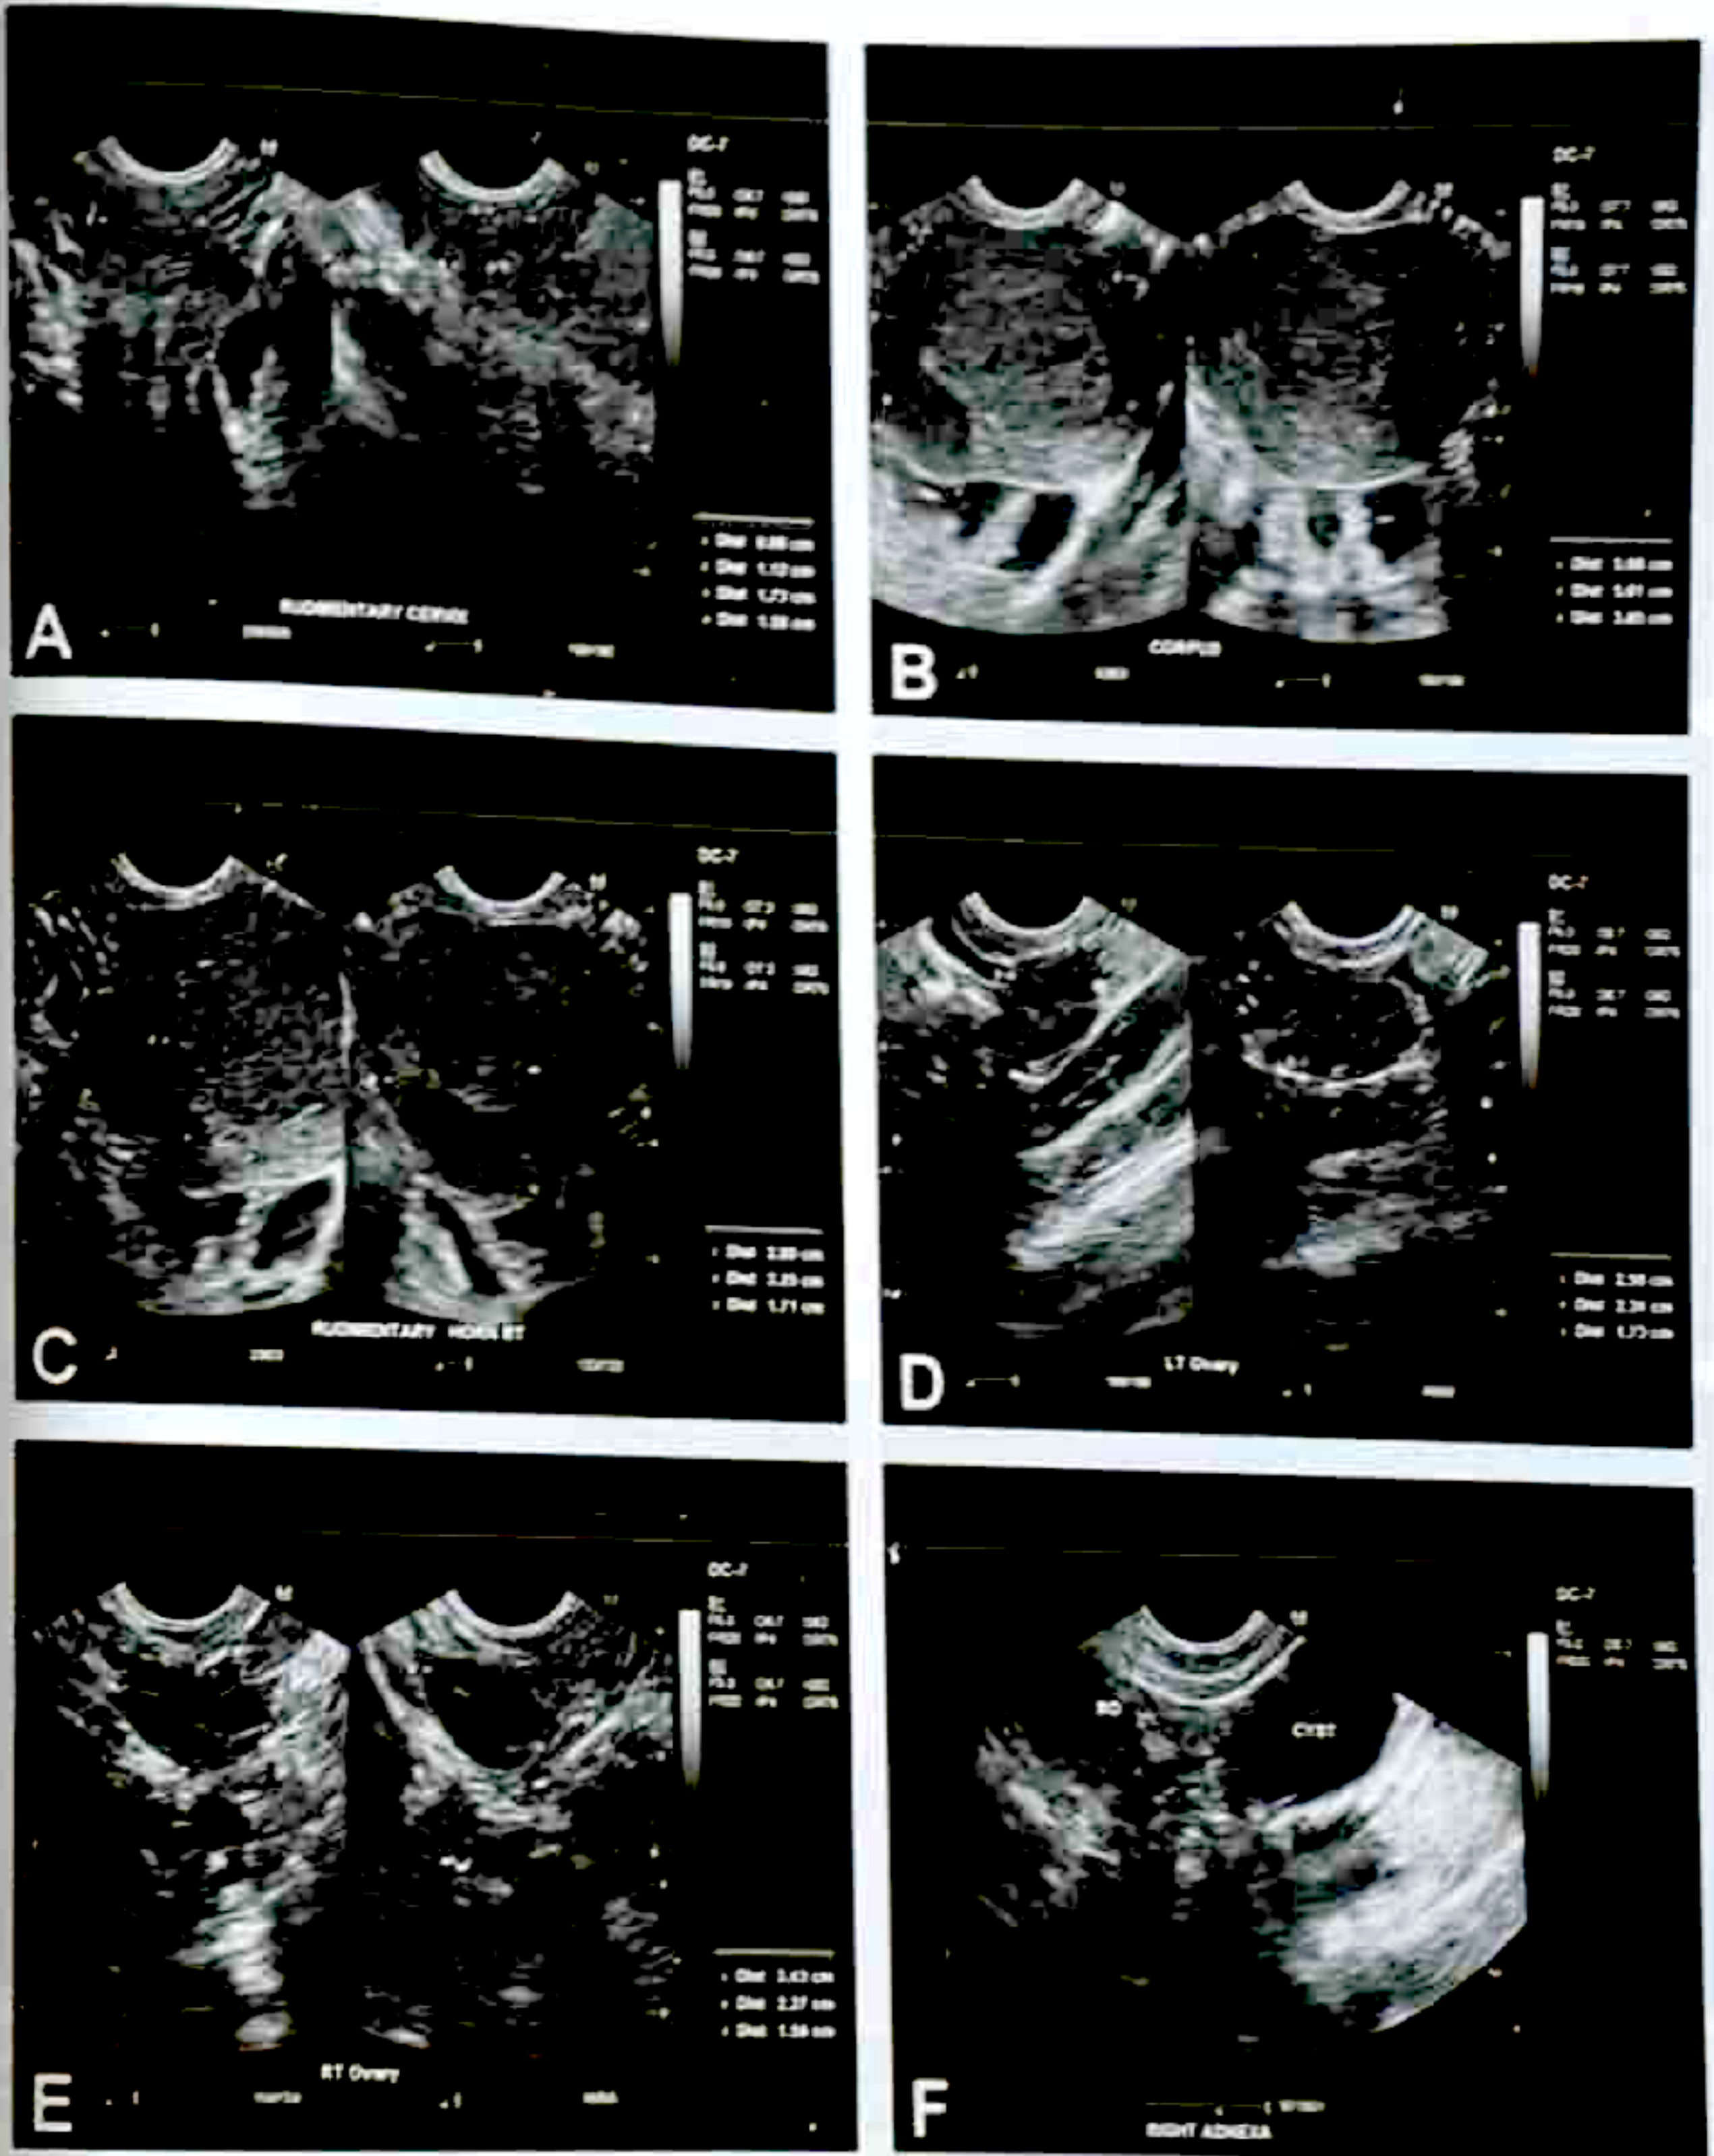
Transrectal ultrasound of first index patient. A) Rudimentary cervix. B) Corpus, endometrial cavity. C) Corpus, rudimentary endometrial cavity. D) Left ovary. E) Right ovary. F) Right para-ovarian cyst in relation to right ovary.
